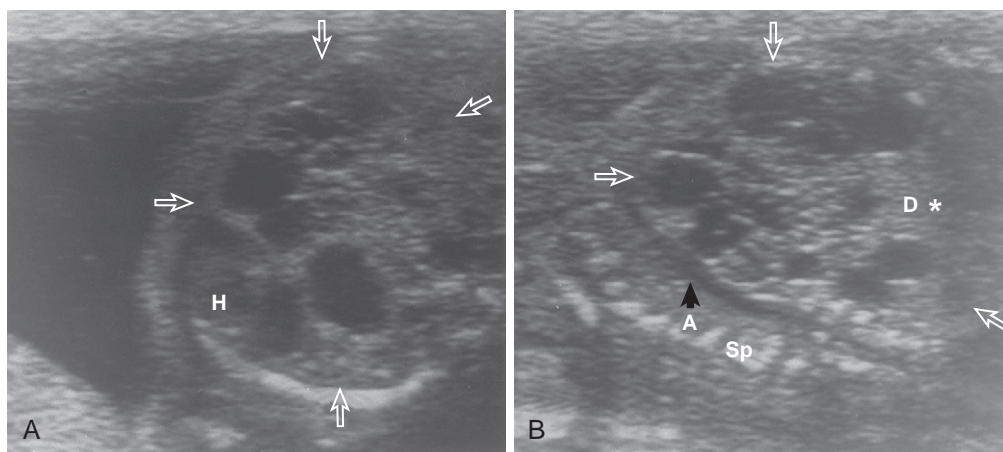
A, Transverse ultrasonographic scan of the fetal thorax at 22 weeks' gestation. A large multicystic mass in the left hemithorax (open arrows) displaces the mediastinum to the right. H, Heart. B, Sagittal ultrasonographic scan of the fetal thorax and abdomen shows a mixed cystic/echogenic mass (open arrows) of the left hemithorax that flattens the left hemidiaphragm (D*). A, Aorta; Sp, spine. This lesion grew and resulted in fetal hydrops. Fetal surgical resection of the affected lobe was performed successfully at 23 weeks' gestation, delivery occurred at 35 weeks' gestation, and the infant survived.
